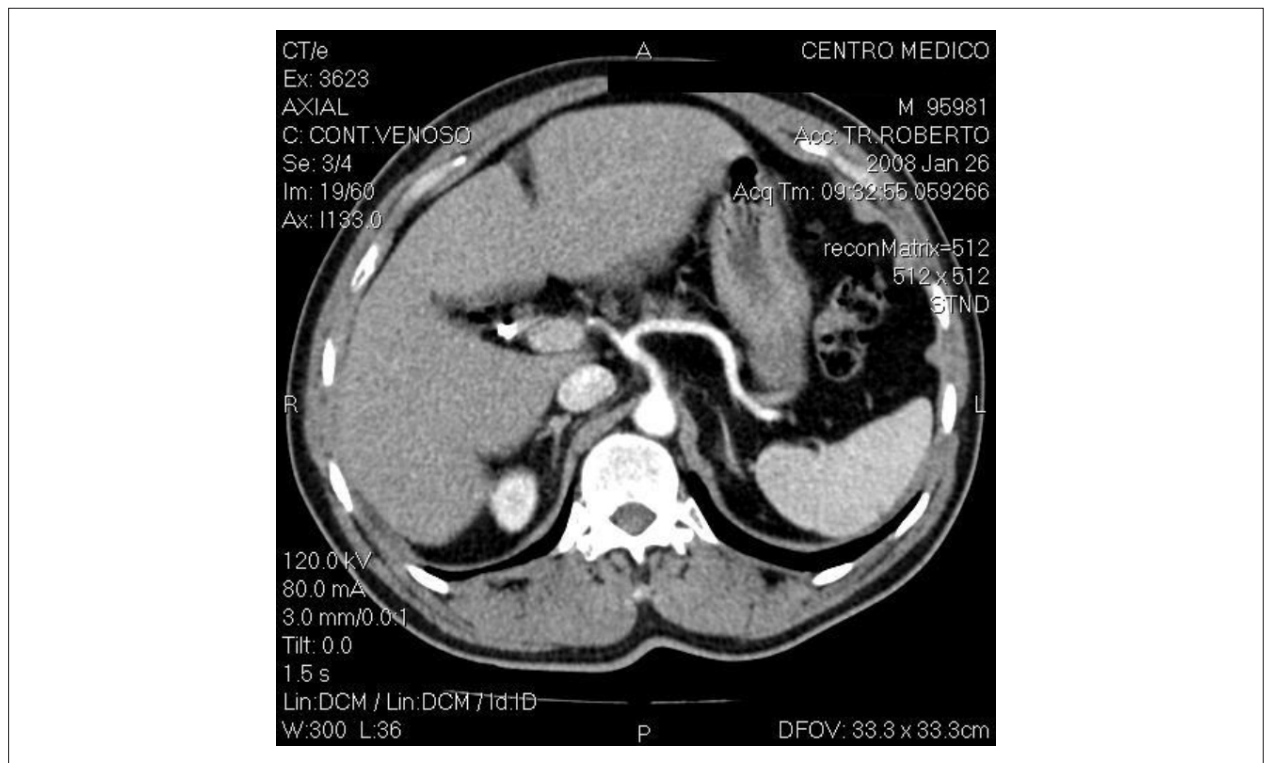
Computed tomography of the adrenal glands of patient with a diagnosis of primary hyperaldosteronism.
